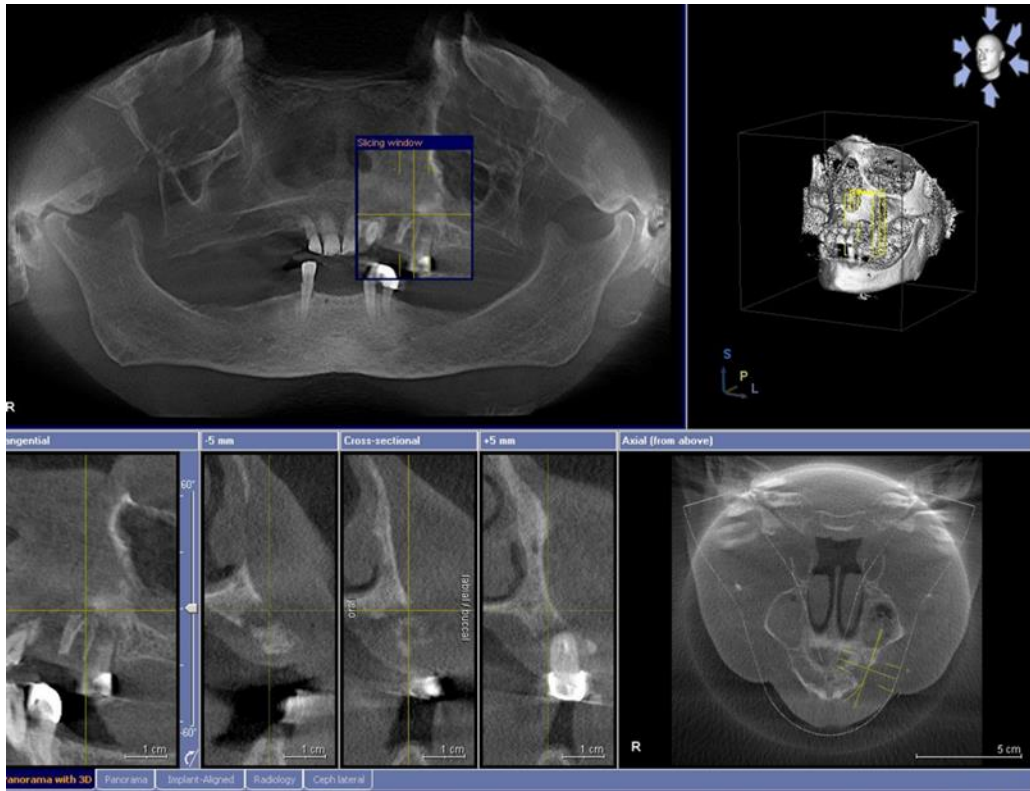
Control computed tomography at 6 months
